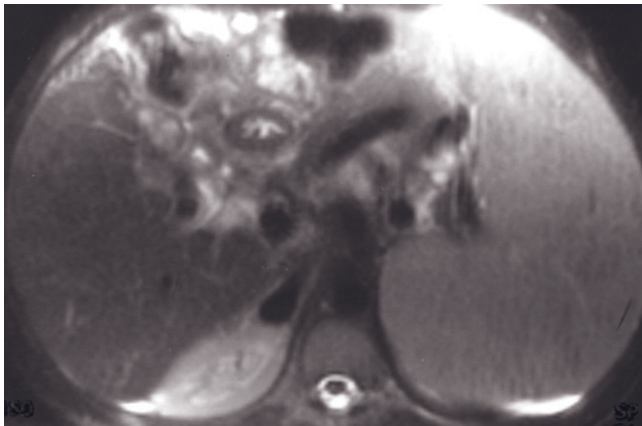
(Continued) T1 single-shot magnetization-prepared gradient-echo (g), and 90-s postgadolinium T1-weighted fat-suppressed spin-echo (h) images in a second patient. The imaging features are comparable to those for the above-described patient. T1-weighted SGE (i), T2-weighted fat suppressed single-shot echo-train spin-echo (j), immediate postgadolinium T1-weighted SGE (k), and 90-s postgadolinium T1-weighted fat-suppressed SGE (l) images in a third patient demonstrate similar findings.
